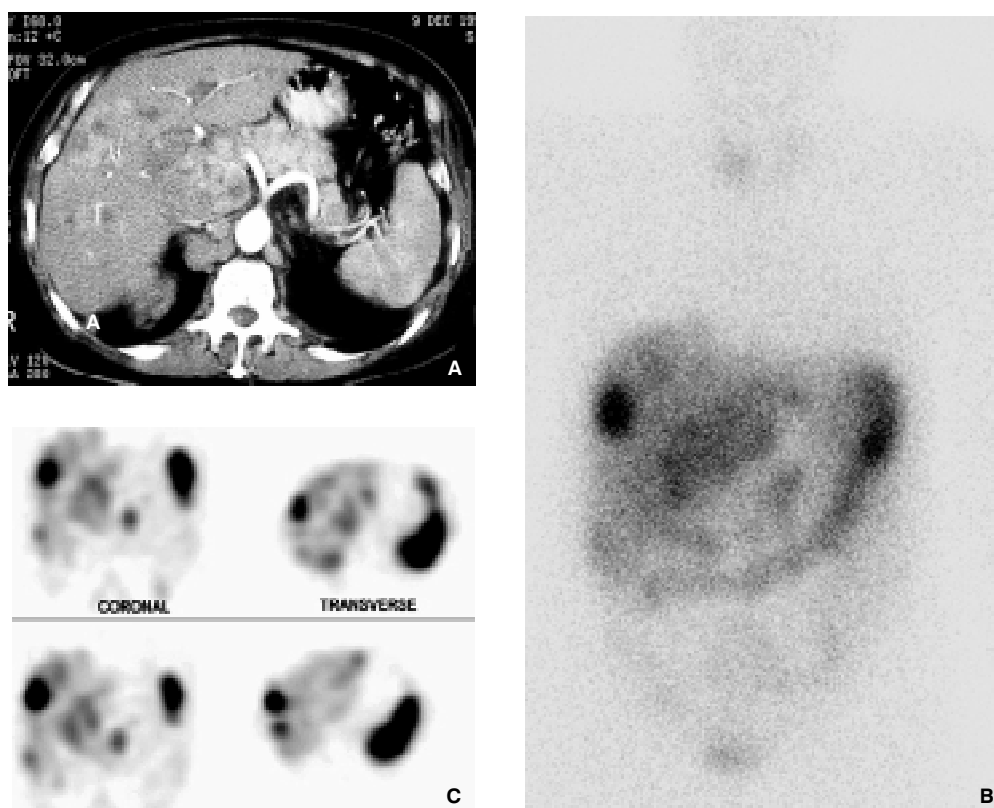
Metastatic carcinoid tumour, at 61-year-old man with primary pancreas head carcinoid. A. Triple phase CT with contrast enhancement (10 mm section) shows pancreatic mass, liver metastases and numerous lymph nodes around the IVC and aorta. B. and C. Whole body and SPECT (coronal and transverse slices) show multiple sites of abnormal uptake within head of pancreas the liver and para-aortic lymph nodes.
